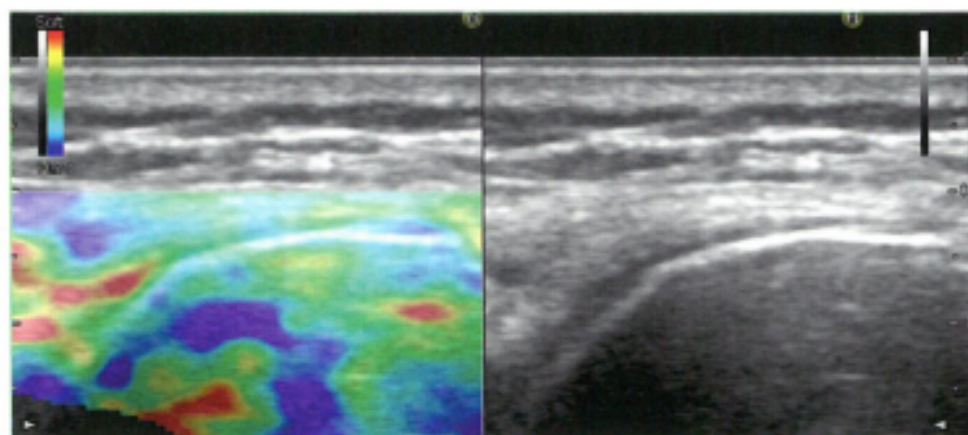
differences in density at the joint, and at its articular spaces can be evaluated (and measured) by high-resolution elastosonography. Densitometry-Elastosonography, Preirus, Hitachi.
